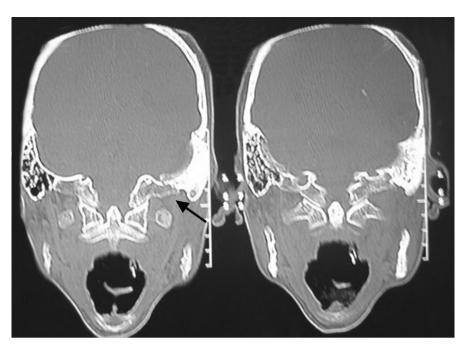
Coronal CT-scan showing fracture involving left jugular foramen (arrow).
